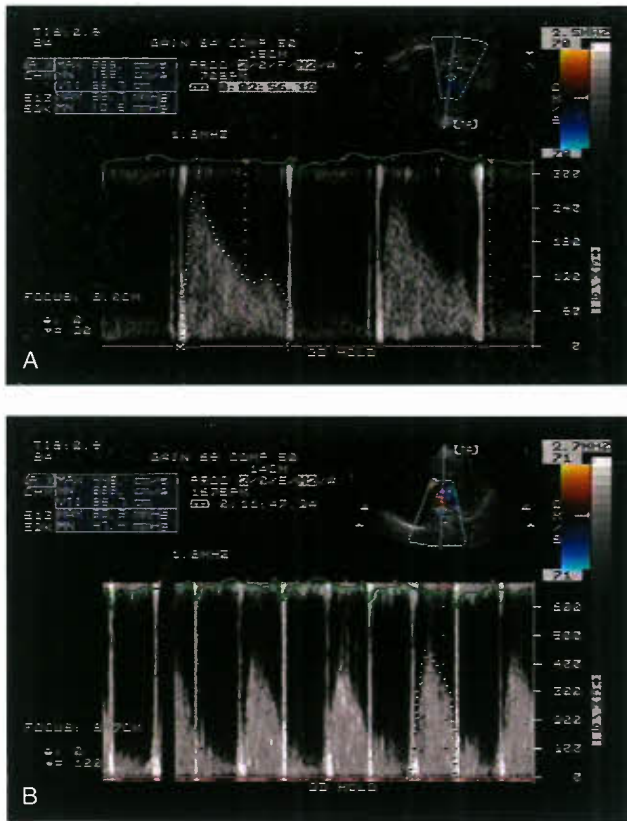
Mitral valve Doppler tracings from an apical four-chamber view in a 16-year-old male with a prosthetic mitral valve at baseline (A) and at peak exercise (B). The mean mitral valve gradient at baseline is 10.5 mm Hg. With exercise, the mean gradient increases to 47 mm Hg.
